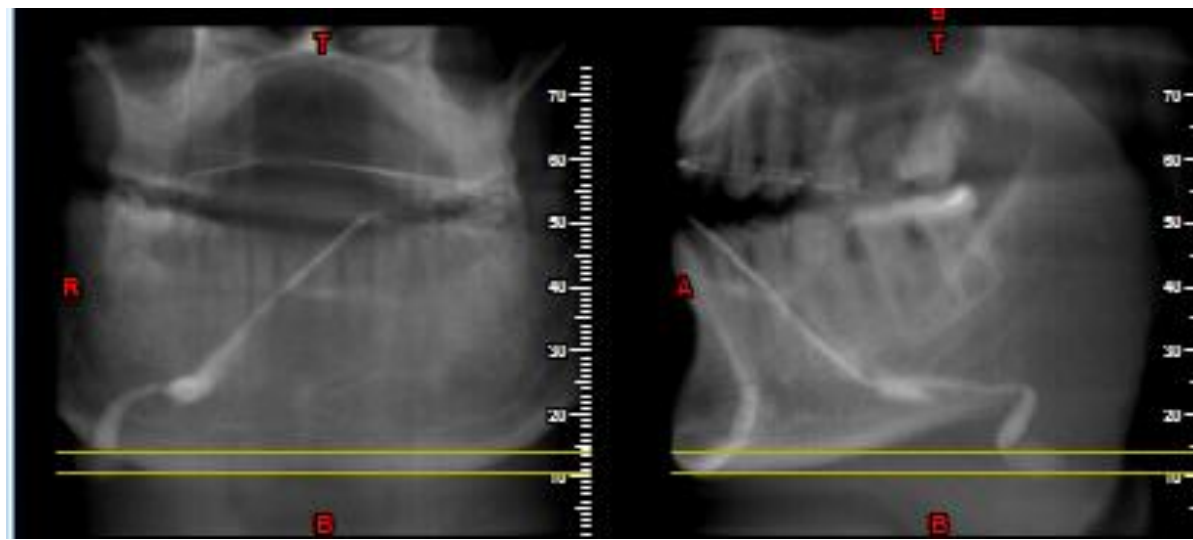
Scout images of CBCT scan taken during the sialography
